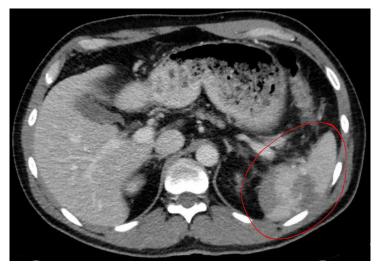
A traumatic splenic rupture as seen on CT scan, the rim at the lower edge demonstrating a sign of free fluid (blood)
